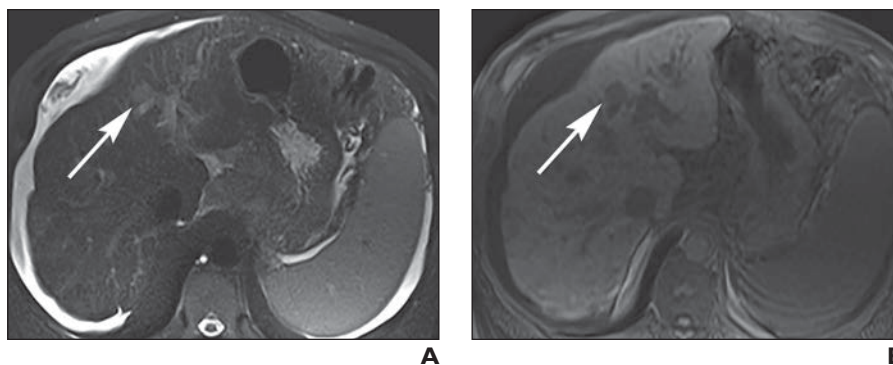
65-year-old man with cirrhosis and cholangiocarcinoma. Observations are vague small area (arrow, A and B) of increased signal intensity on T2-weighted image, decreased signal intensity on T1-weighted image, arterial phase hyperenhancement, and progressive hyperintensity on later phase images. Biopsy was performed because of features worrisome for cholangiocarcinoma.
